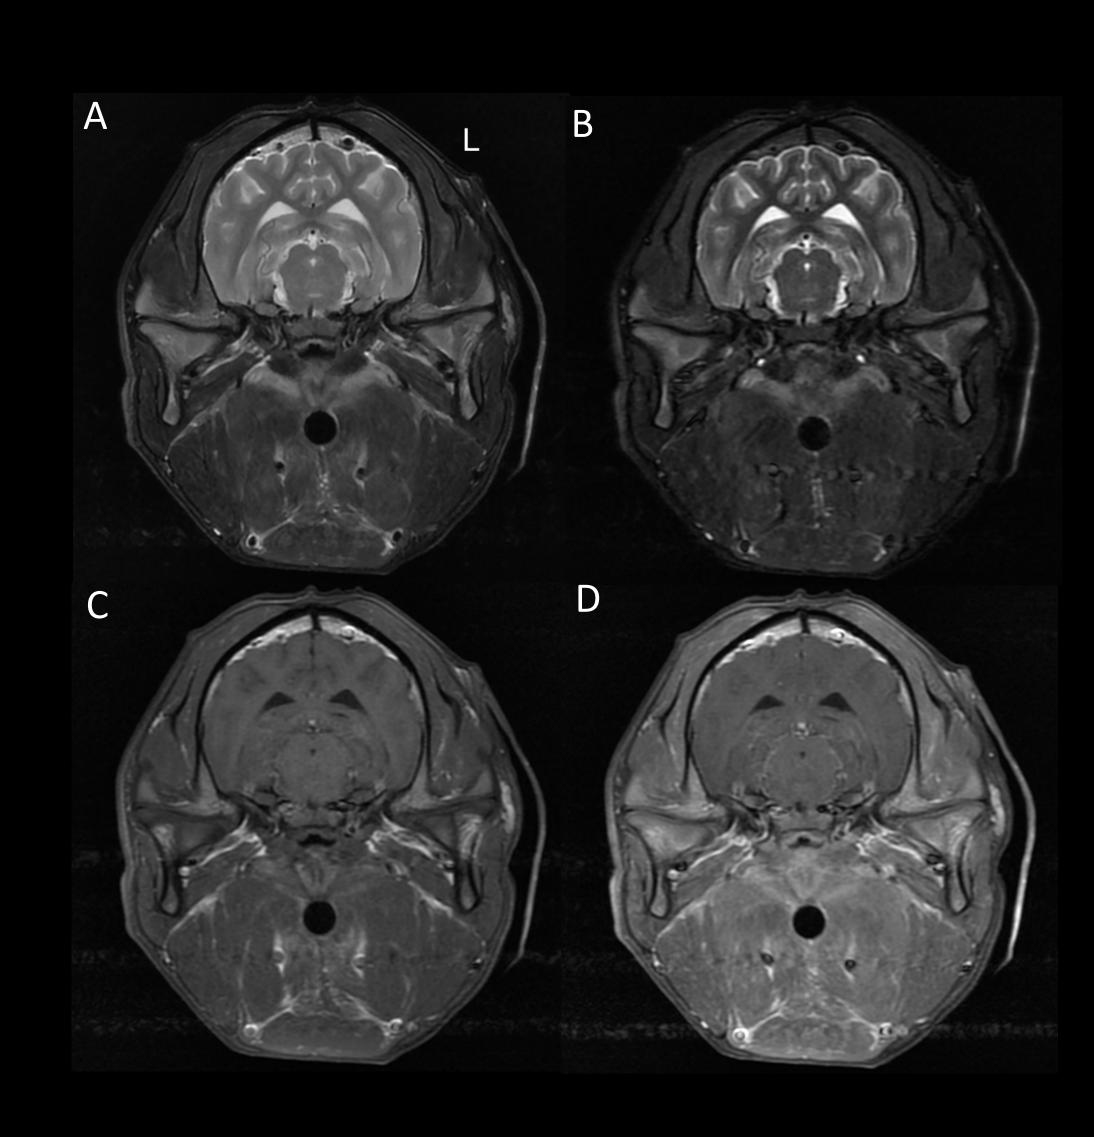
MRI of the head. A, Transverse T2w; B, STIR; C, T1w precontrast; D, T1w post-contrast images with a 3 mm slice thickness. There is bilateral and symmetric increase in volume of the geniohyoid and mylohyoid muscles and moderate bilateral hypotrophy of the masseter and temporal muscles. All the affected muscles are heterogeneously hyperintense on T2w and STIR sequences and heterogeneously enhancing in the T1w post-contrast sequence.
